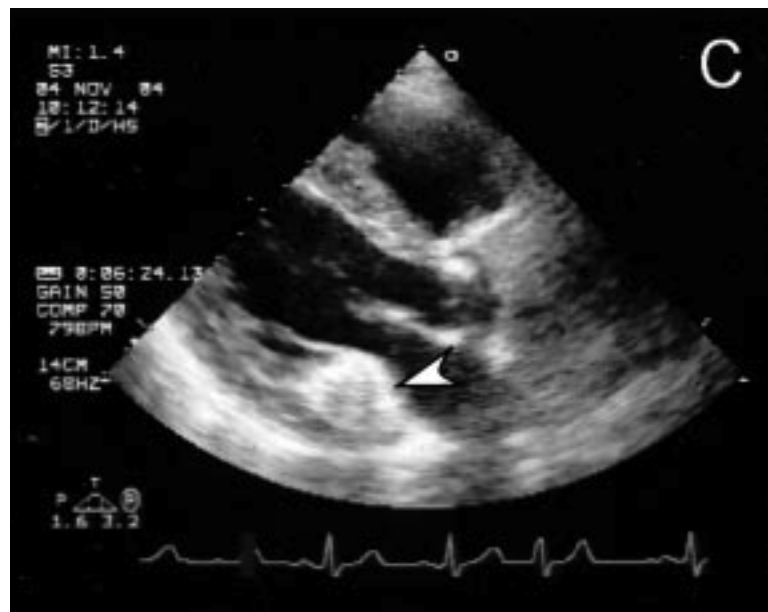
Echocardiogram of abnormal calcified mass on the mitral valve. Acoustic shadowing and hyperechoic behavior are evident. Image used with permission (Yokoyama *et al.*, 2007).
